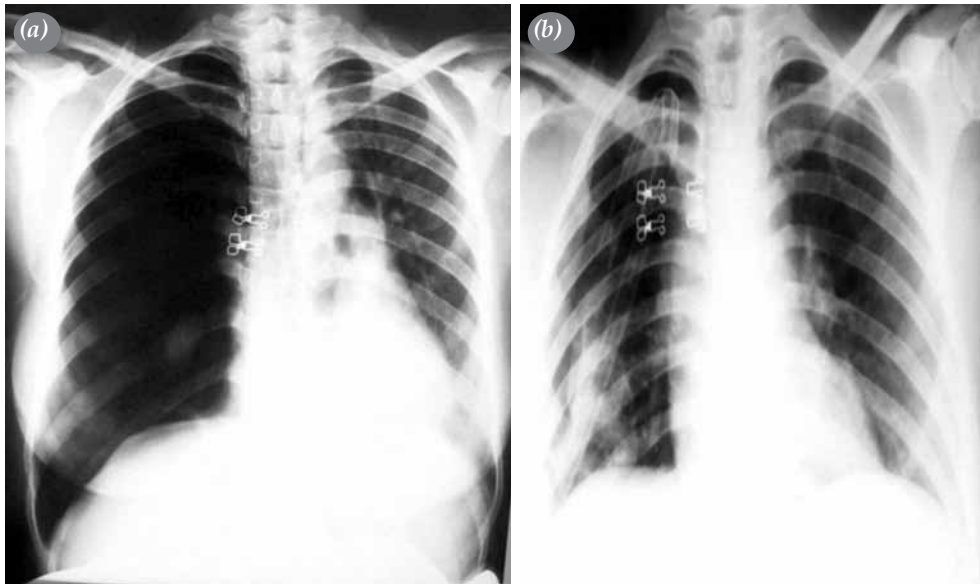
(a) Chest X-ray showing the right total pneumothorax (first pneumothorax). (b) Chest X-ray after chest tube insertion.
